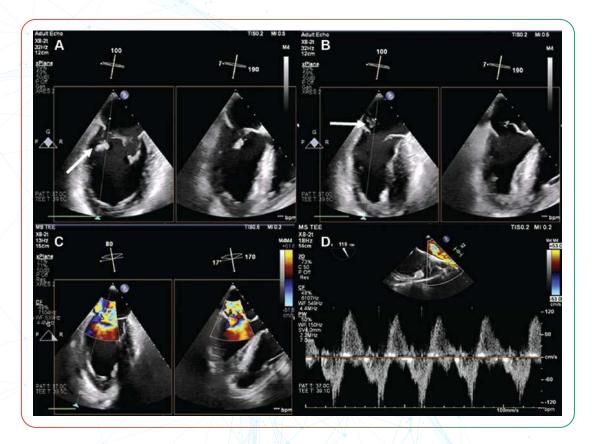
Two-dimensional TEE mitral commissural view with biplane imaging showing the mitral valve, left ventricle, and left atrium in - diastole (A) and systole (B). With color Doppler (C) and pulsed-wave Doppler analysis of the systolic flow reversal in the pulmonary veins (D), severe MR
